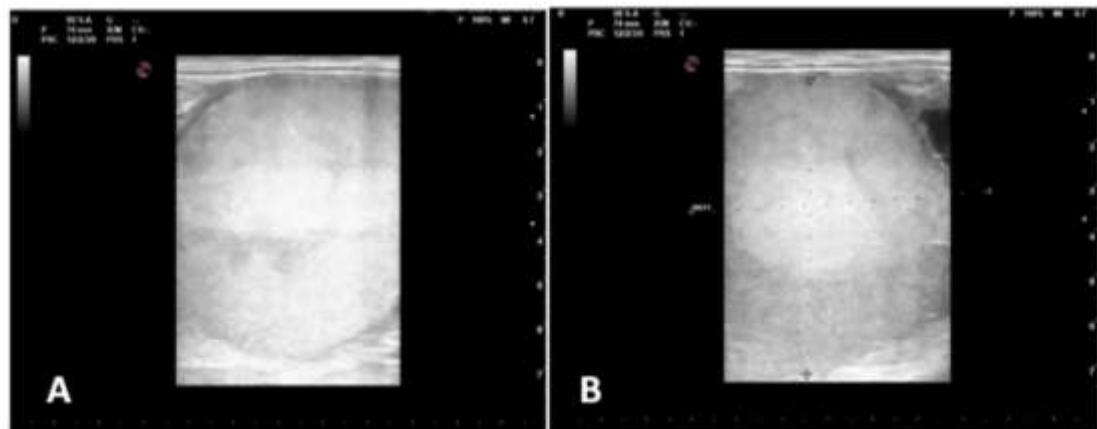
Ultrasound images of the mare's right ovary, showing the presence of a well-defined echogenic structure with a uniform internal appearance, suggestive of an ovarian hematoma. A: Image taken 24 hours after administration of dinoprost tromethamine (Lutalyse®, Zoetis), the structure was approximately 63x54mm. B: Image taken 72 hours after PGF2 $\alpha$ , the structure was approximately 66x65mm.
